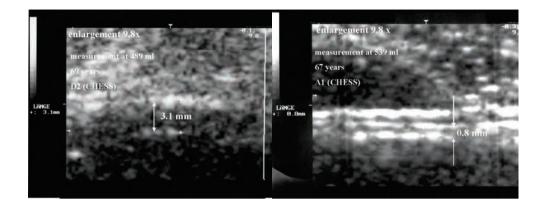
Sonographic measurement of detrusor wall thickness in a patient with severe obstruction (D2 according CHESS-classification, left image) compared to a patient without obstruction but detrusor hypocontractility (A1 according CHESS-classification, $W_{max} 2.7 \text{ W/m}^2$, right image). Both patients experienced recurrent urinary retention and were clinically classified as obstructed previously.
